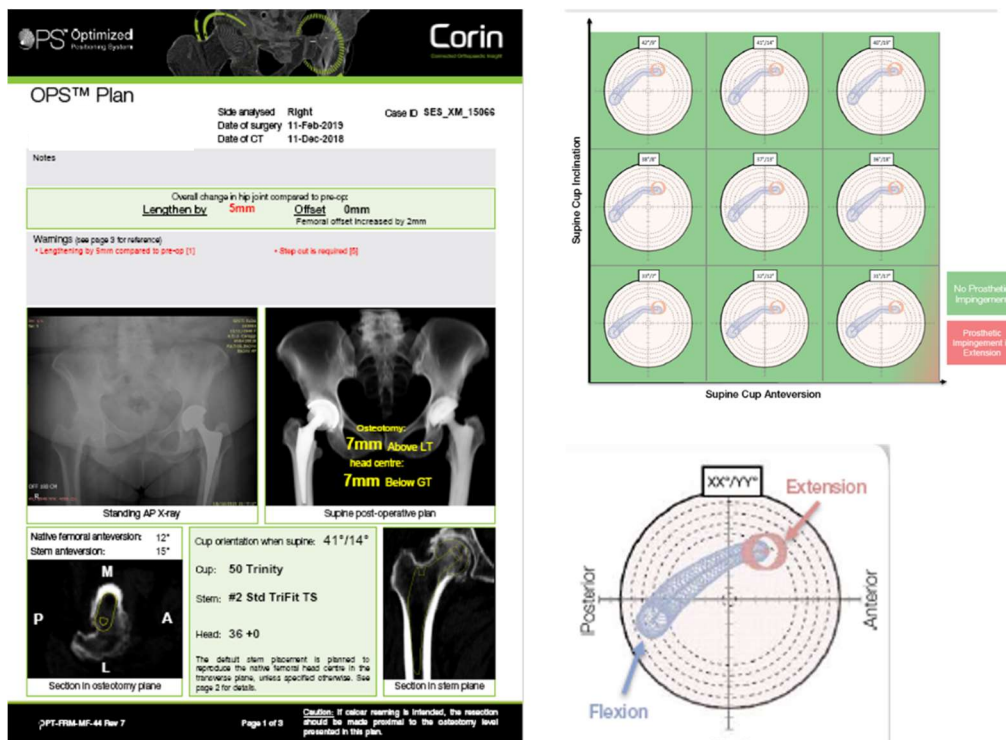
The OPS™ report contains the planned size of the implant which best fit with the CT reconstructed anatomy of the patient, the leg length discrepancy correction and the level of femur neck osteotomy, a graphic with a series of combination of inclination/version of the cup and the relative risk of impingement and edge loading planned in the functional x-rays.
